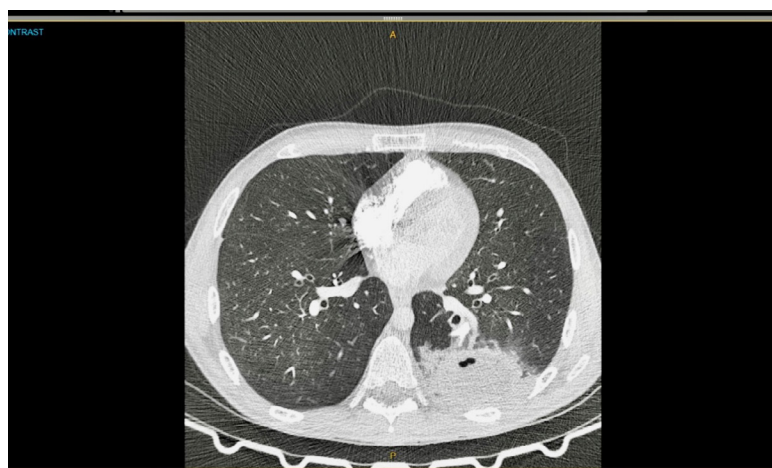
Axial CT image demonstrating a thick-walled cavity with an air–fluid level in the left lower lobe, consistent with a lung abscess.
